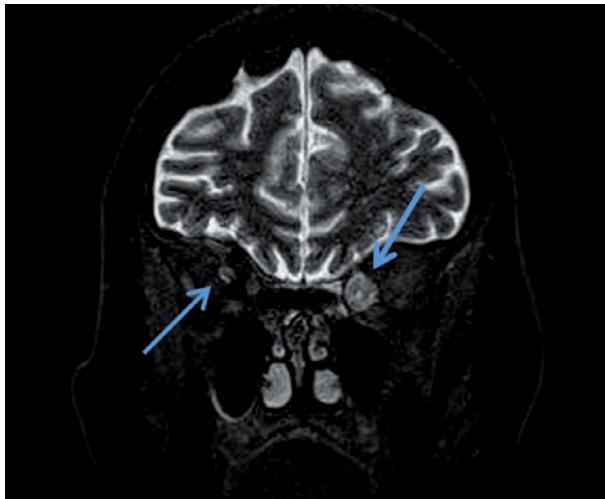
The mass within the left medial rectus muscle and discrete enlargement of the right medial rectus muscle on MRI short tau inversion recovery (STIR) sequences in coronal plane.
